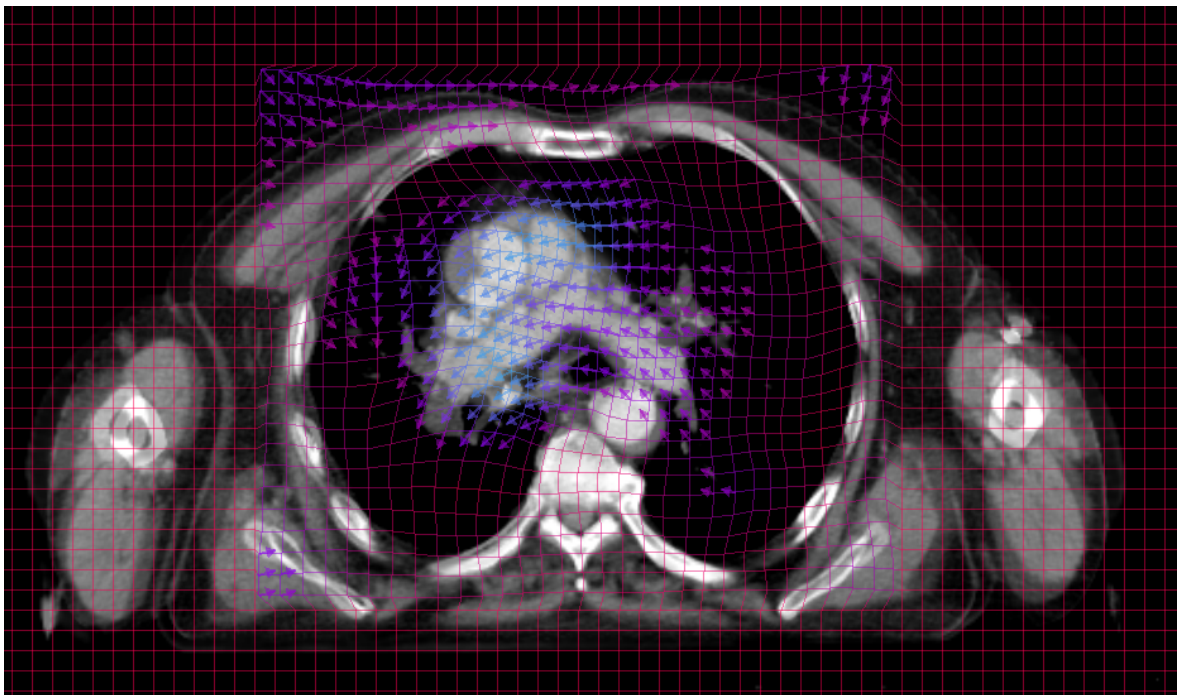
Direction vectors with a whole organ region of interest Region of interest was set to include the whole lung. Purple lines demonstrate the direction the initial planning CT scan was warped to align with the re-irradiation planning CT
